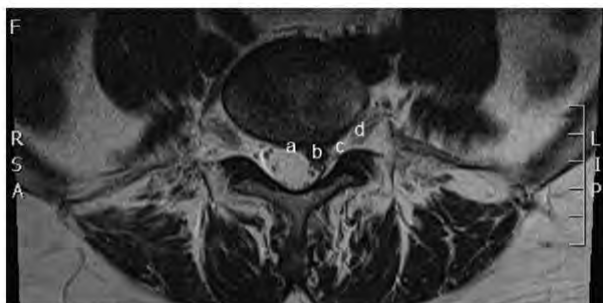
Axial T2-weighted lumbar MRI slice showing the anatomic zones for classifying the location of disc herniation according to the combined task forces of the North American Spine Society, the American Society of Spine Radiology and the American Society of Neuroradiology. This patient has a paracentral herniation (b). a = central; b = paracentral; c = foraminal; d = extraforaminal.
